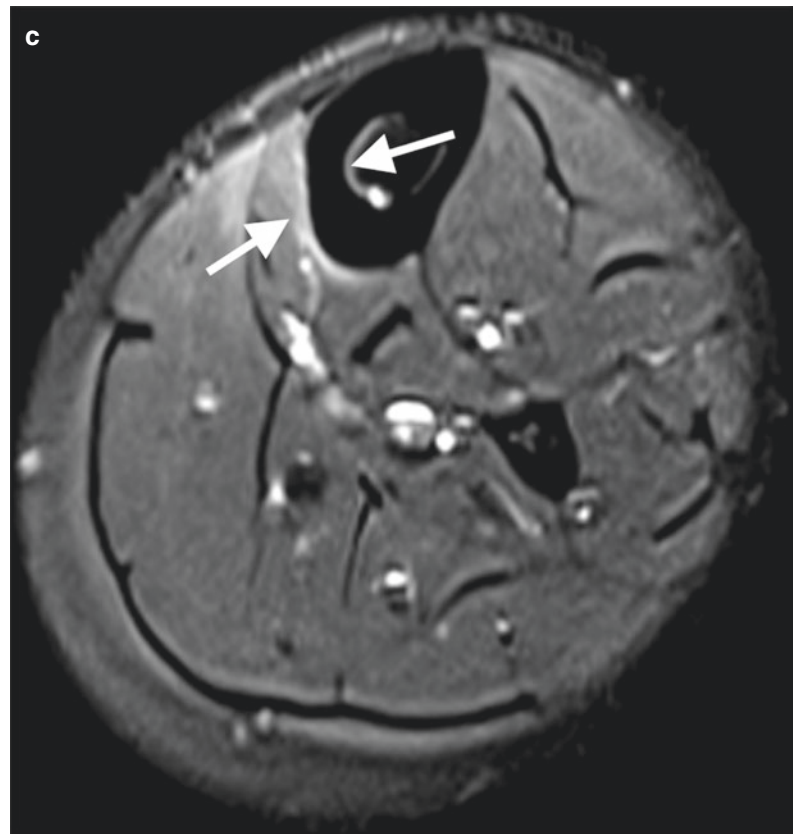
MRI of a 19-year-old runner with the female athlete triad and right-sided hip pain. (a) Coronal T1-weighted MR image of the pelvis demonstrates paucity of body fat and signal abnormality of the right femoral neck. (b) Coronal fat-suppressed T2-weighted MR image
